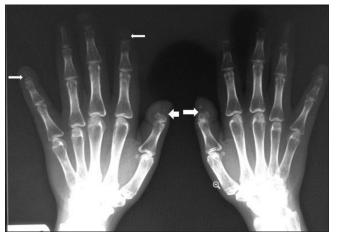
Radiograph of the right and left hands, Anterior—posterior view. Showing transverse band of osteolysis involving the distal phalanges of the thumb, second, third, and fifth fingers bilaterally (arrows). Osteoporosis of the distal phalanges when compared to the carpal bones also noted
